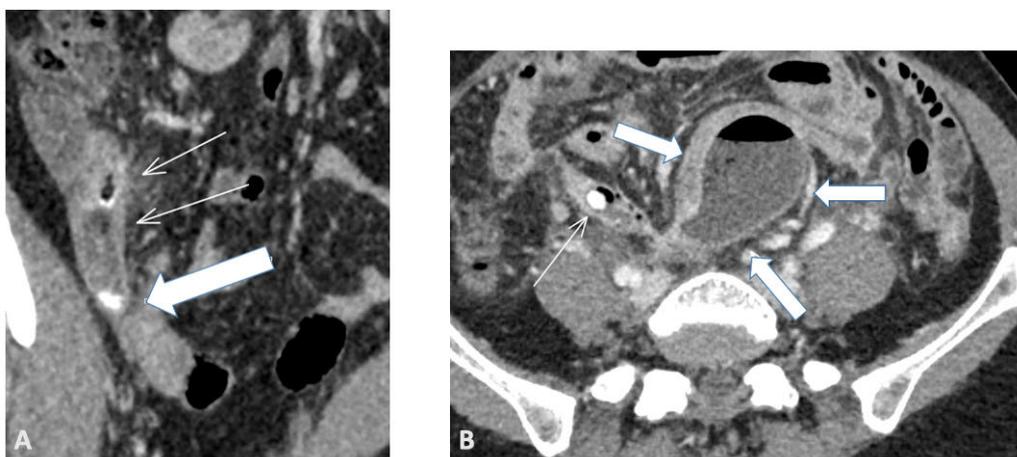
CT image of complicated acute appendicitis. A) Complicated by appendicolith (thin arrows: appendix, thick arrow: appendicolith). B) Complicated by large abscesses and appendicolith (thin arrow: appendicolith, thick arrows: abscess).
